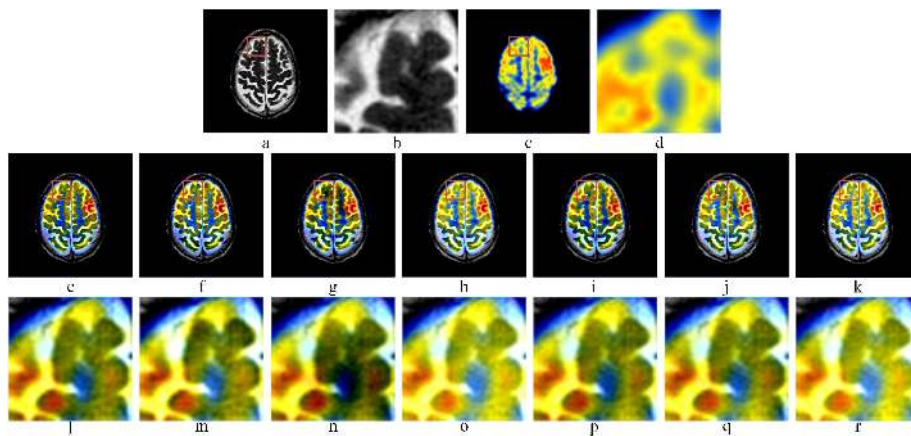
MRI-PET image fusion experiments, (a) and (c) are MRI and PET source images respectively. (b) and (d) are the local detailed images of (a) and (c) respectively. (e), (f), (g), (h), (i), (j) and (k) are the fused images of ASR, JCPD, MST, NSST, NSCT, NSCT-PC and proposed methods respectively. (l), (m), (n), (o), (p), (q), and (r), are local detailed information of (e), (f), (g), (h), (i), (j) and (k) respectively.
